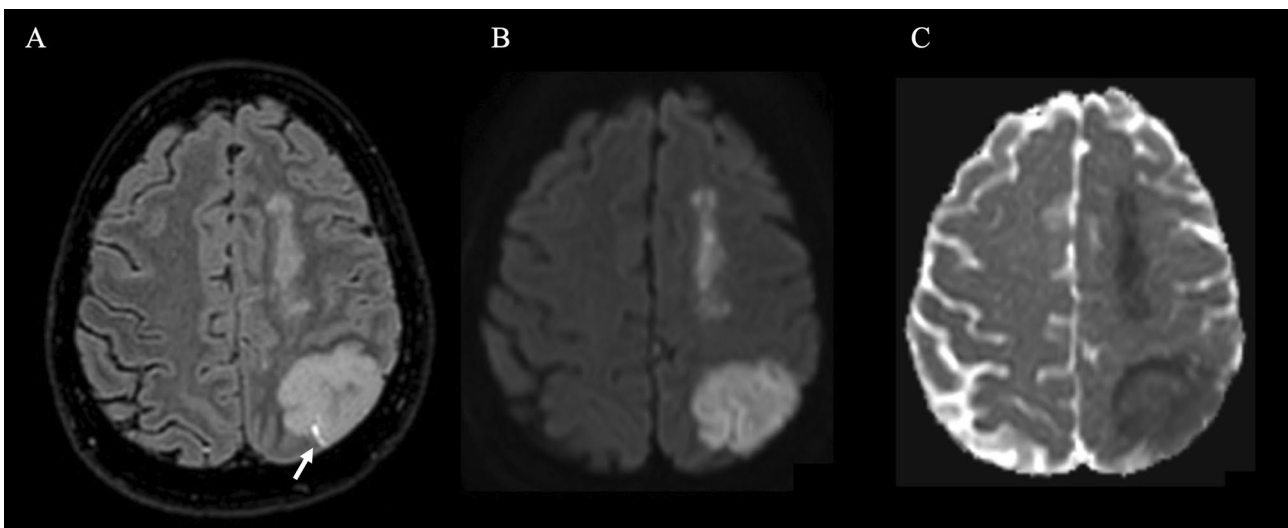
Axial FLAIR (a), DWI (b) and Apparent Diffusion Coefficient (c) images show ischemic stroke with watershed distribution, involving left frontal parasagittal area and the left posterior parietal lobe. Note also SAH in the left parietal convexity (arrow in A)
